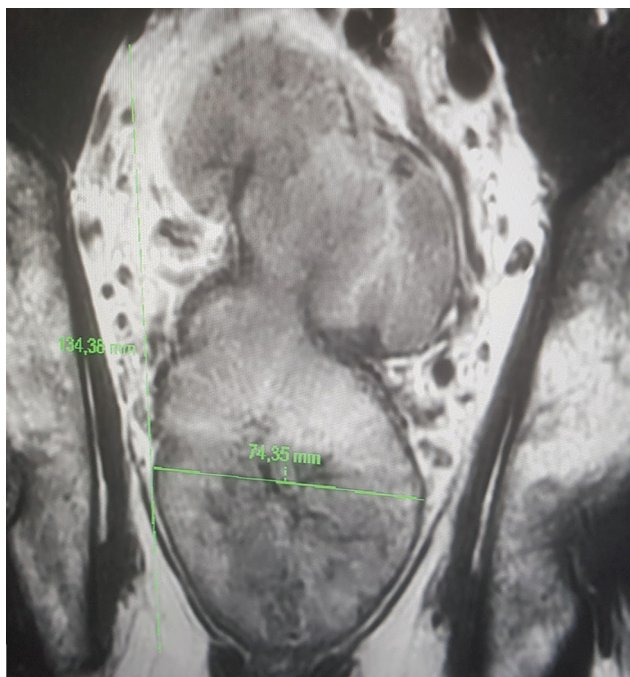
Magnetic resonance imaging, coronal section. Image suggestive of neoplastic process with diameters of 13.4 × 7.4 cm involving the mucosal, muscular and serous layer.
